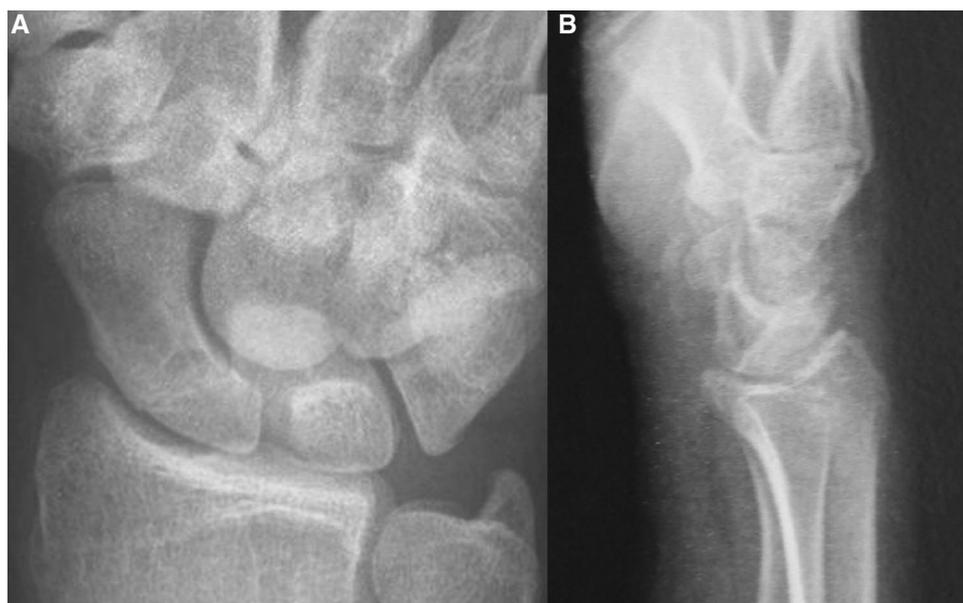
Anteroposterior (a) and lateral (b) radiographs of the right wrist joint at 24 months postoperative showing no evidence of scaphoid necrosis or arthritic changes of the radiocarpal joint. Note the bone anchor next to the cannulated screw
